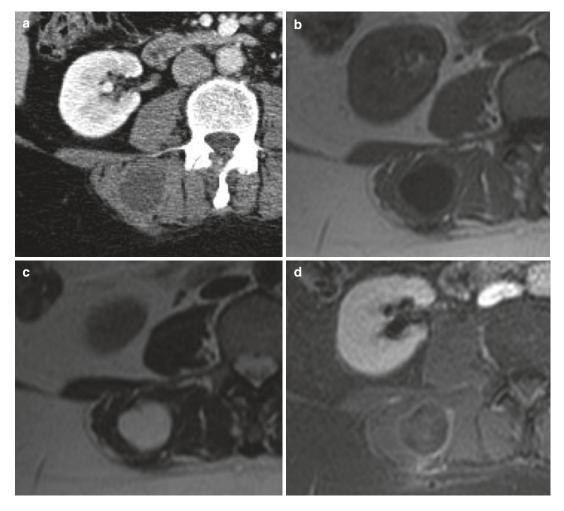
Intramuscular myxoma in the autochthonous back muscles. (a) Axial CT-scan. (b) Axial T1-weighted MR image. (c) Axial T2-weighted MR image. (d) Axial T1-weighted MR image after gadolinium contrast injection. On CT, the myxoma presents as a well-demarcated
